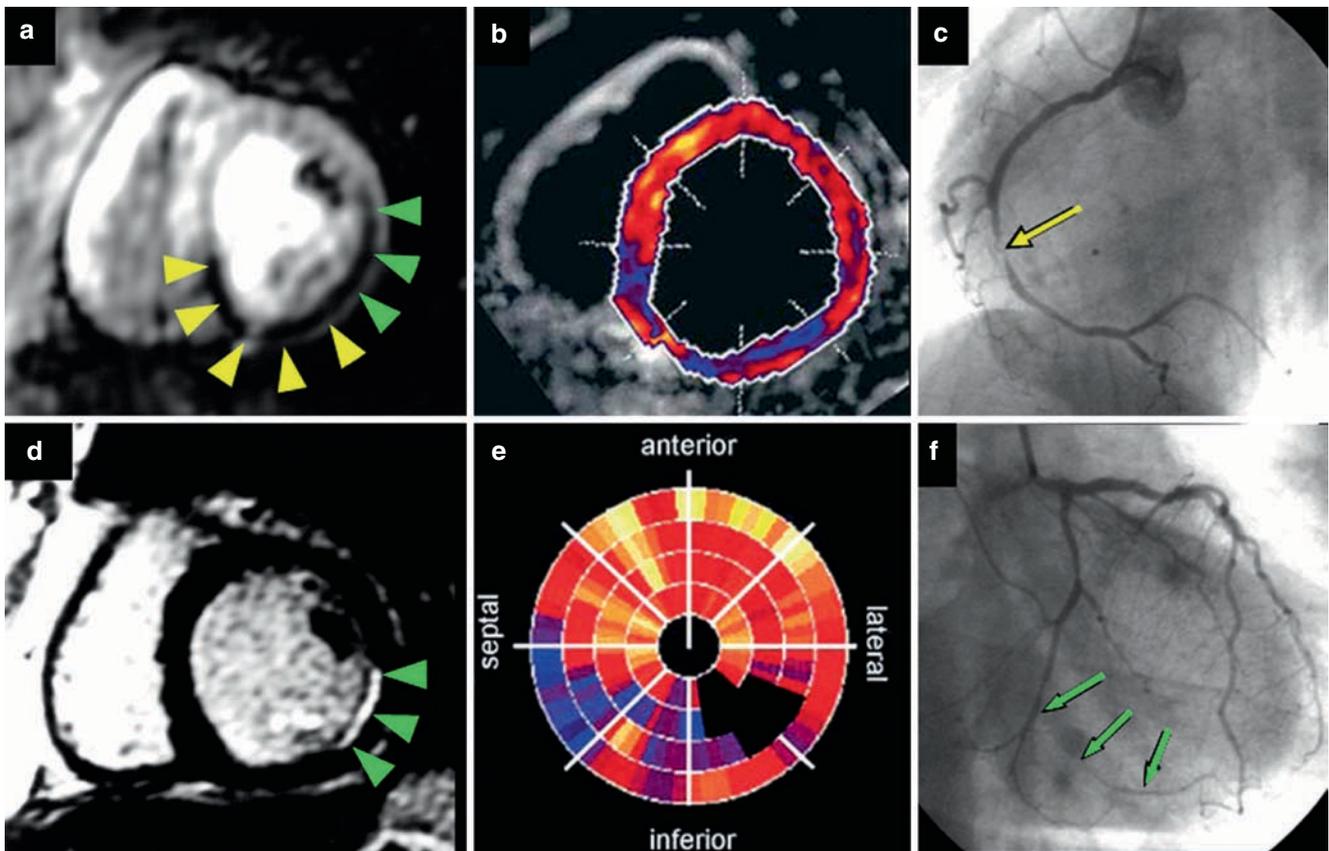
In a 48-year-old woman with atypical chest pain and dyspnea during exercise, a first-pass perfusion MR study (a) reveals a perfusion deficit in the sub-endocardial layer of the inferior wall extending into the basal portion of the septum and the lateral wall. A parametric map (b) demonstrates contrast medium wash-in kinetics for the slice shown in (a). On this parametric map, linear upslope data above/below the threshold (mean of controls – 1.75 SD) are encoded in shades of red and blue, respectively. The sub-endocardial zone of hypo-perfusion is also detected by the computer algorithm. Subsequent conventional X-ray coronary angiography confirmed stenosis of the right coronary artery (c). In the same patient, delayed enhancement MR imaging (d) revealed a small sub-endocardial
